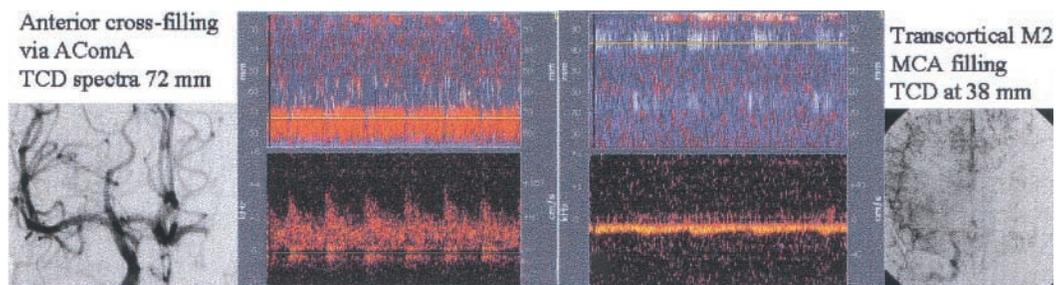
Collateral flow signature. A 17-year-old woman with a cardioembolic left terminal internal carotid artery (ICA) occlusion and a National Institutes of Health Stroke Scale (NIHSS) score of 14 points was brought to the hospital 18 hours after symptom onset. Her power motion mode Doppler/transcranial Doppler (PMD/TCD) showed a reversed left A1 anterior cerebral artery, indicating anterior cross-filling (left panel), and a retrograde blunted flow signal at the depths of the M2 middle cerebral artery (MCA) subdivision, suggesting transcortical flow collateralization (right panel). These findings were confirmed at digital subtraction angiography performed within 1 hour of PMD/TCD. Note that PMD also displays a weak high-intensity signal at the depths of ICA bifurcation (left panel) and reversed flow at this location on the right panel. These flow signatures may represent stenotic flow signals and partial retrograde filling of the terminal ICA that together with transcortical collateral flow explains the relatively low NIHSS scores in the presence of a terminal ICA occlusion.
